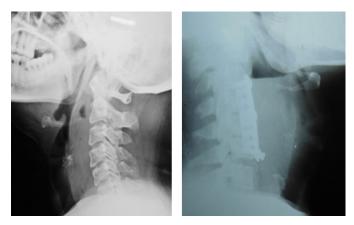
Lateral radiograph of neck showing prevertebral gas shadow (left) and air-fluid level in another patient who had undergone plating and anterior fixation of C3-C6 (right)
